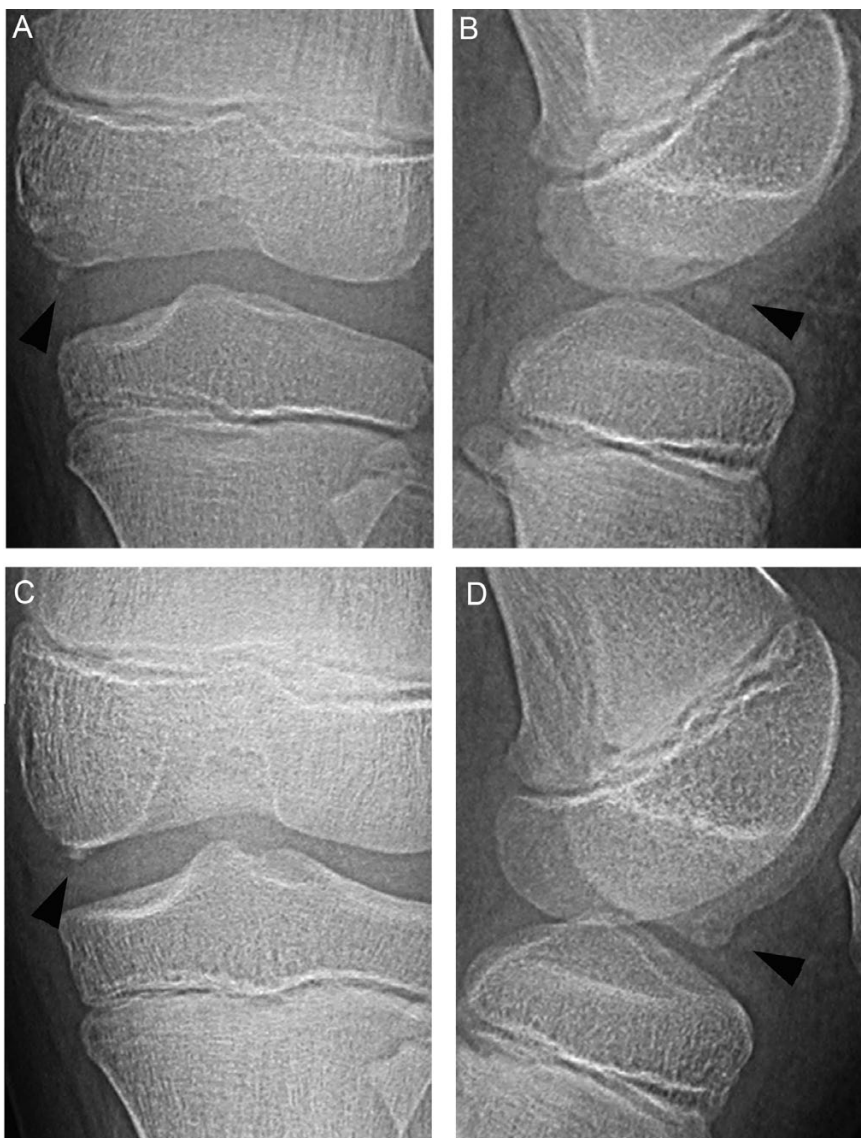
Plain radiographs of the left knee. (A) an anteroposterior view, (B) a lateral view. (A,B) At the 2nd visit to our outpatient clinic a free-body like bony fragment is detected in the medial compartment of the left knee (arrowheads). (C,D) 18 months after Figure 1A, the bony fragment detected is united with medial femoral condyle just like a bone protuberance (arrowheads).
